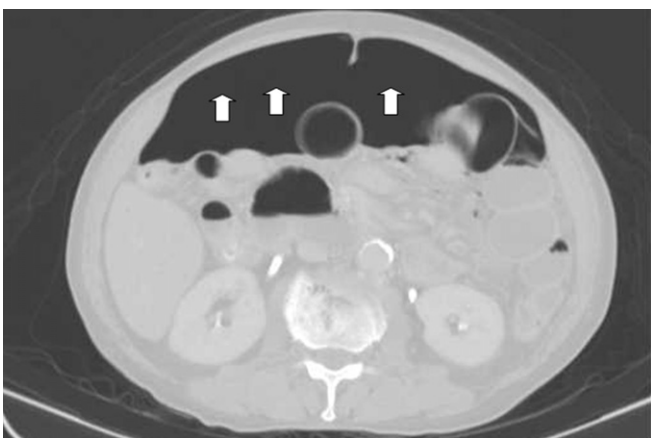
Computed tomography of the abdomen showed massive intraperitoneal free air (arrows), which indicates hollow organ perforation.
